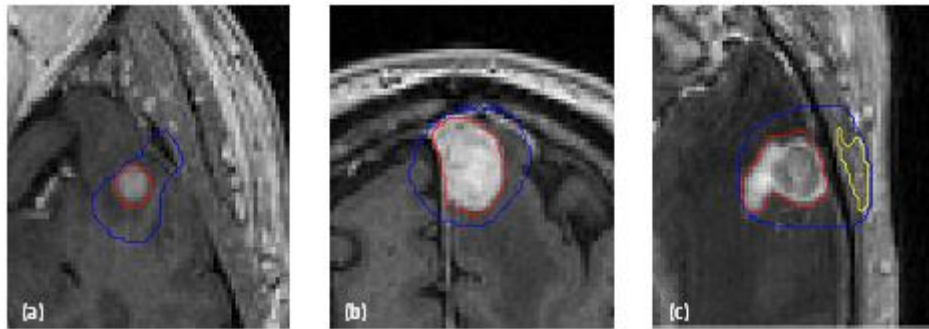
Examples of brain tumour segmentation on MR images (red contour), starting from the ROI bounding region (blue contour). A difficult case is shown in (c), where a lengthened hyper-intense region of the head skin is detected by FCM clustering (yellow contour), but it is removed using the shape-based control.
